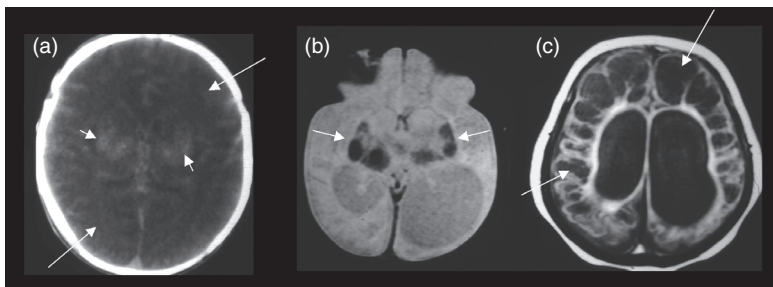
Term combined HIE: subacute phase with (a) basal ganglia and thalamic high densities (short arrows) plus cerebral low densities (long arrows) on CT; chronic phase with (b) basal ganglia and thalamic hypointense mineralization (arrows) on axial GRE plus (c) hypointense cystic encephalomalacia (arrows) on axial T1 MRI.
